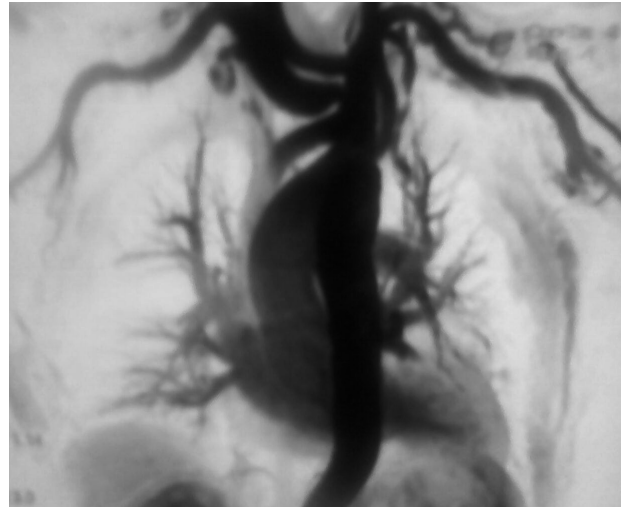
Recoarctation of aorta on Magnetic resonance imagining
